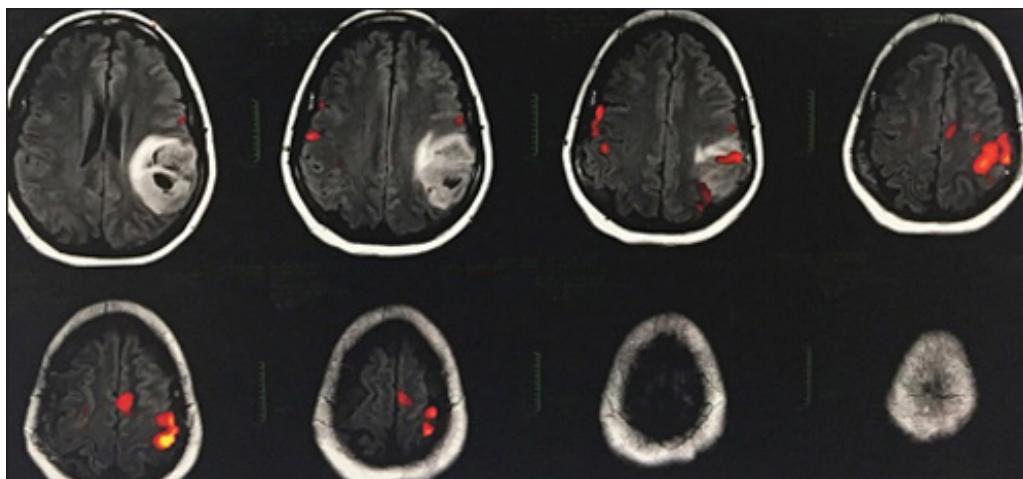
Functional magnetic resonance imaging and glioma: Red spots of the functional areas for the speech test near/between the tumor
